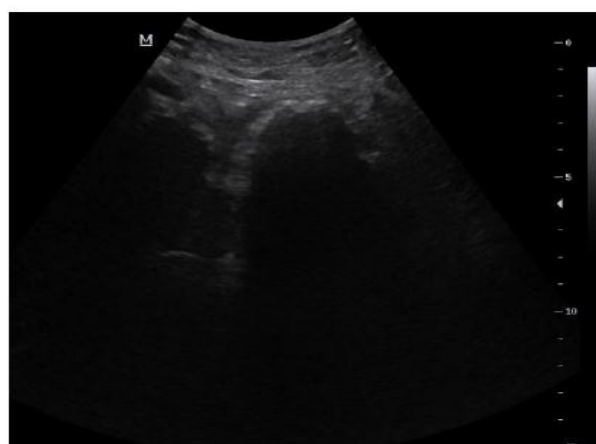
Ultrasound evaluation revealed a hyperreflective curvilinear area with dense posterior
